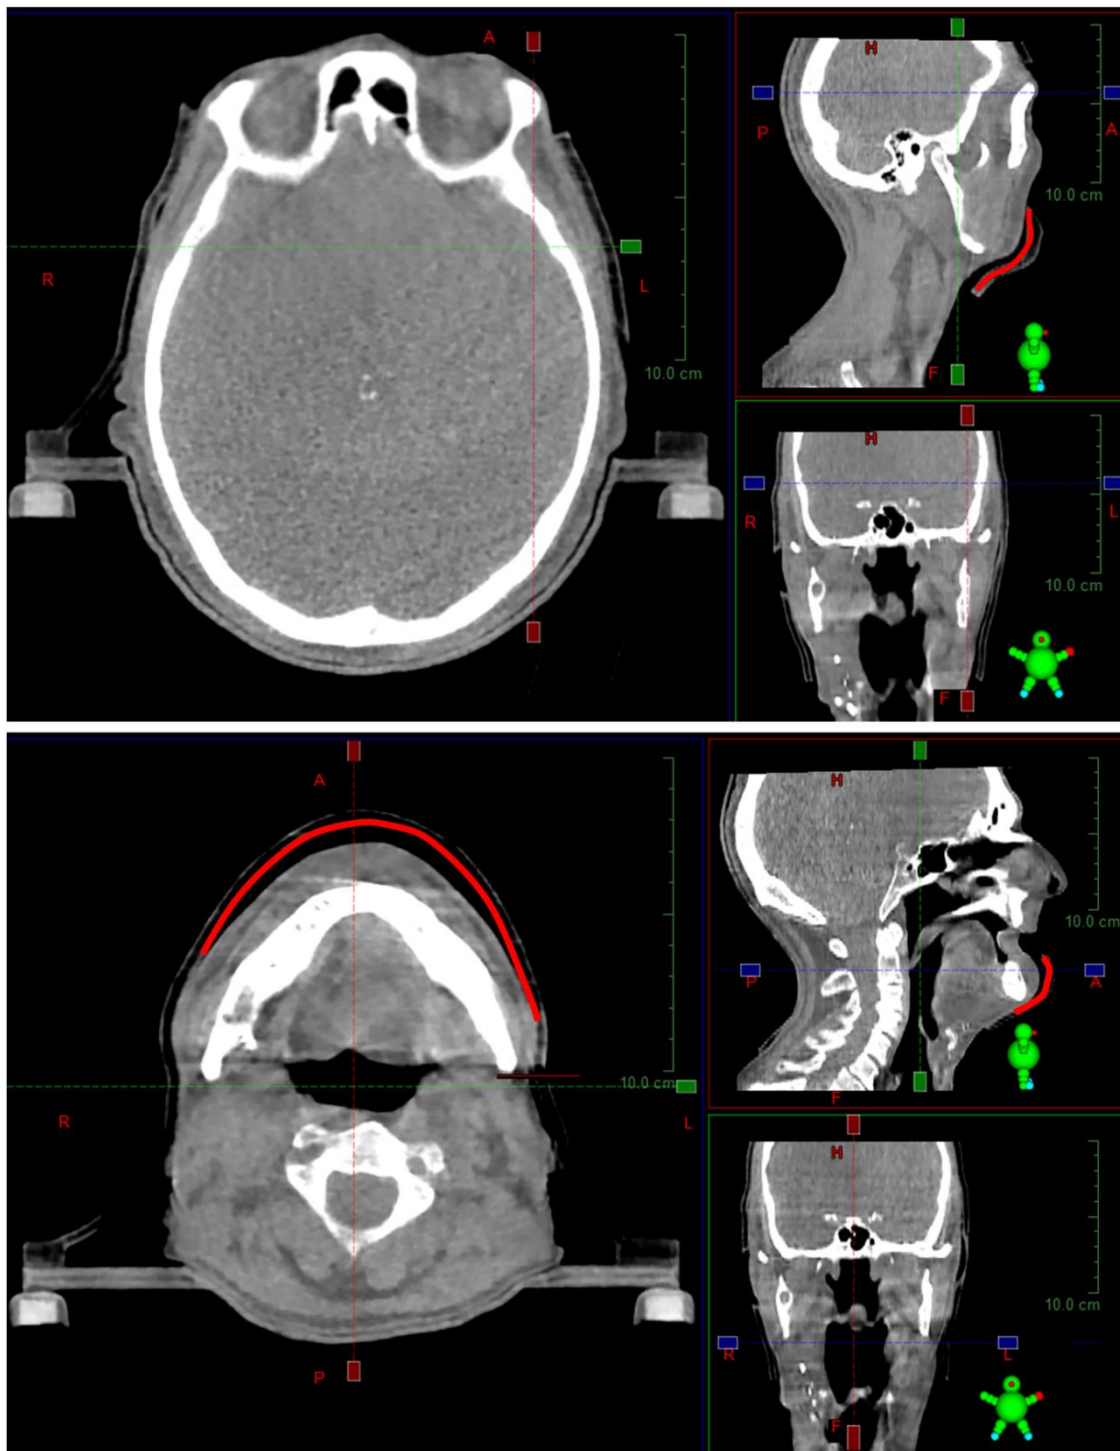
Visualization of the second study CBCT, i.e. in the second of seven weeks of treatment, for patient A immobilized with a 3D printed immobilization. The visualized regions are the temporal bone region (a) and the mandible region (b). The inner border of the 3D printed immobilization is locally marked in red to highlight the gap in the mandible region observed for this particular patient.
